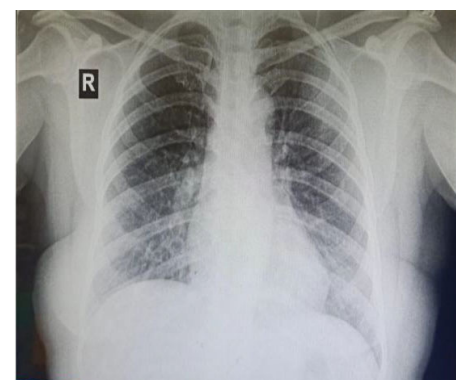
Chest radiograph suggested a pneumonia
